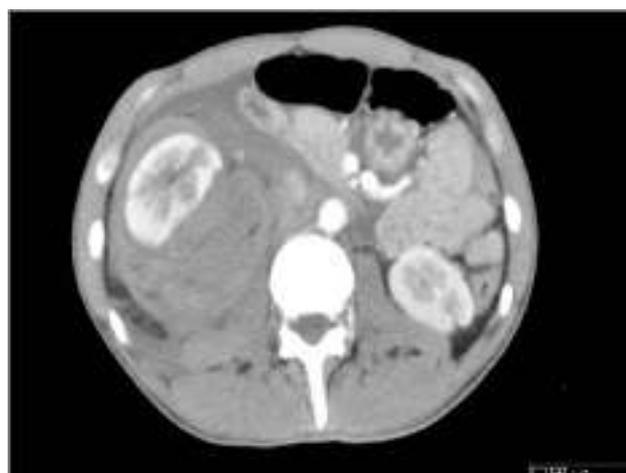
Perirenal Hemorrhage CT Image 1
